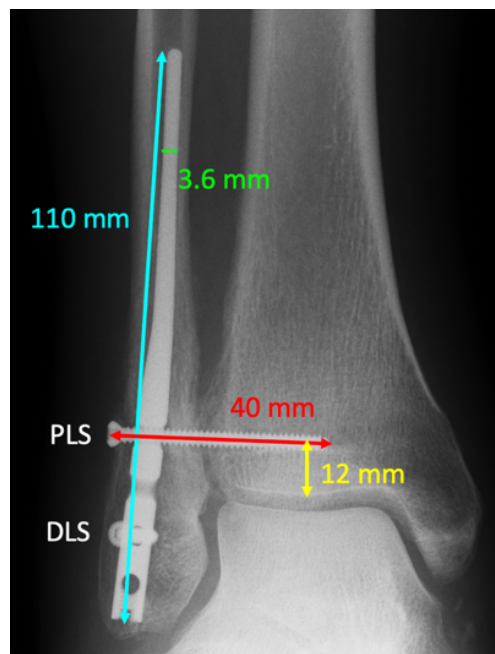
Radiographic assessment of the fibular intramedullary nail construct.
